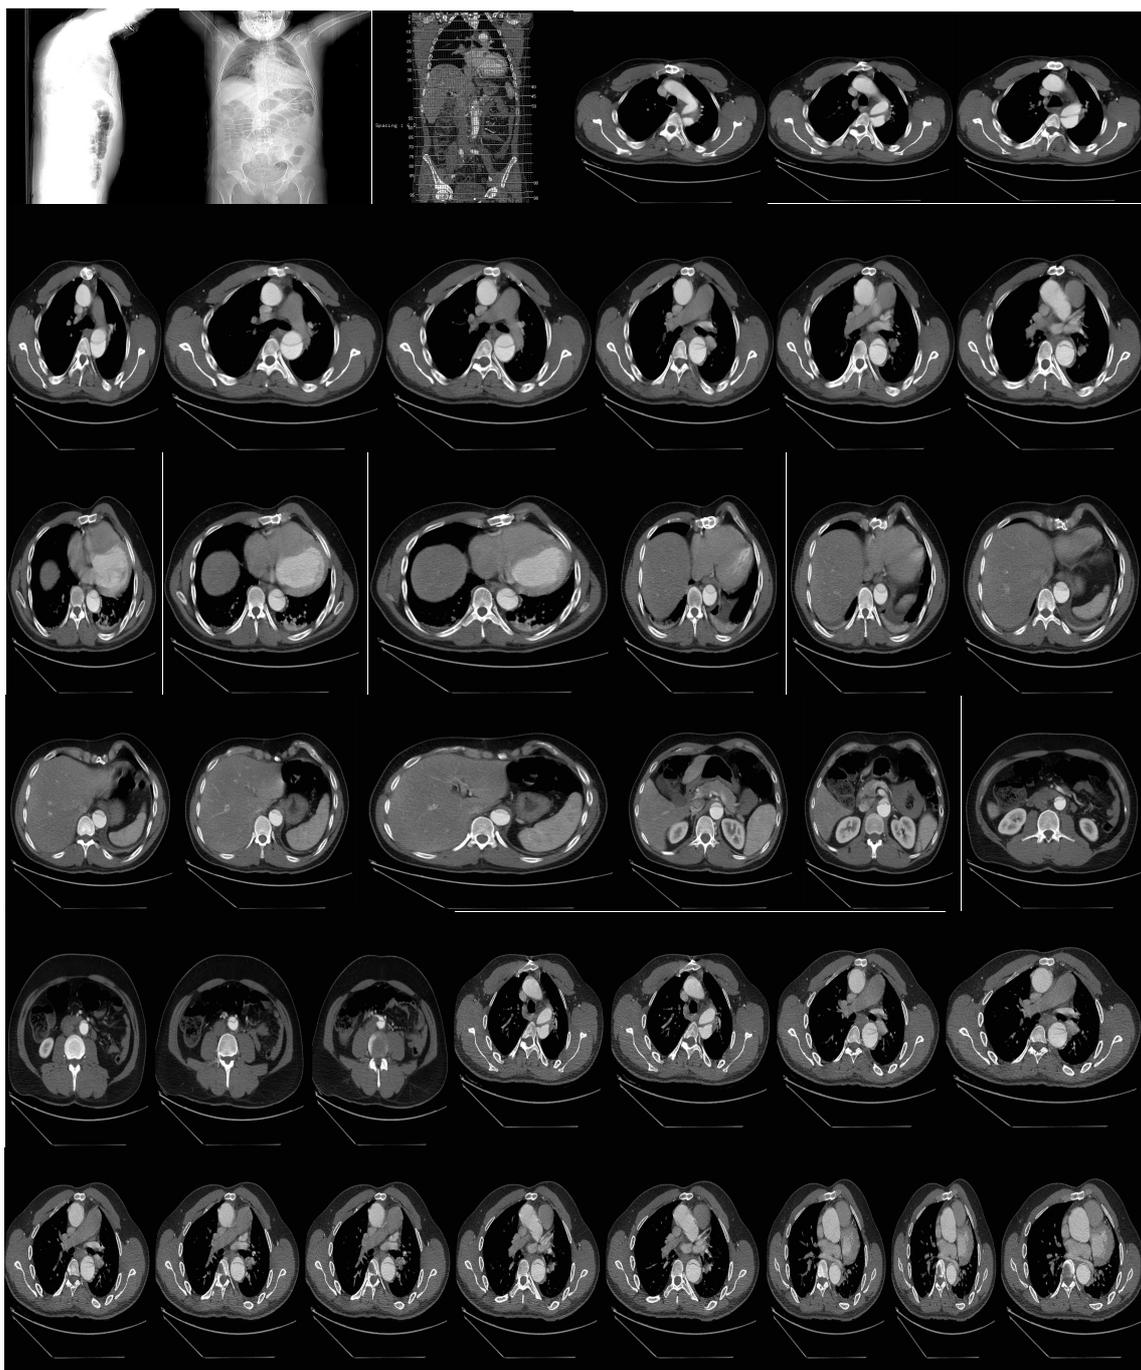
Computed tomography angiography before stent implantation
